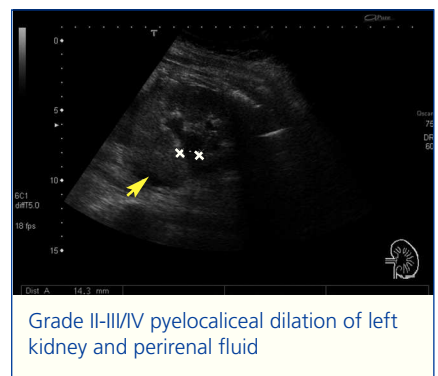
Left renal ultrasound.
